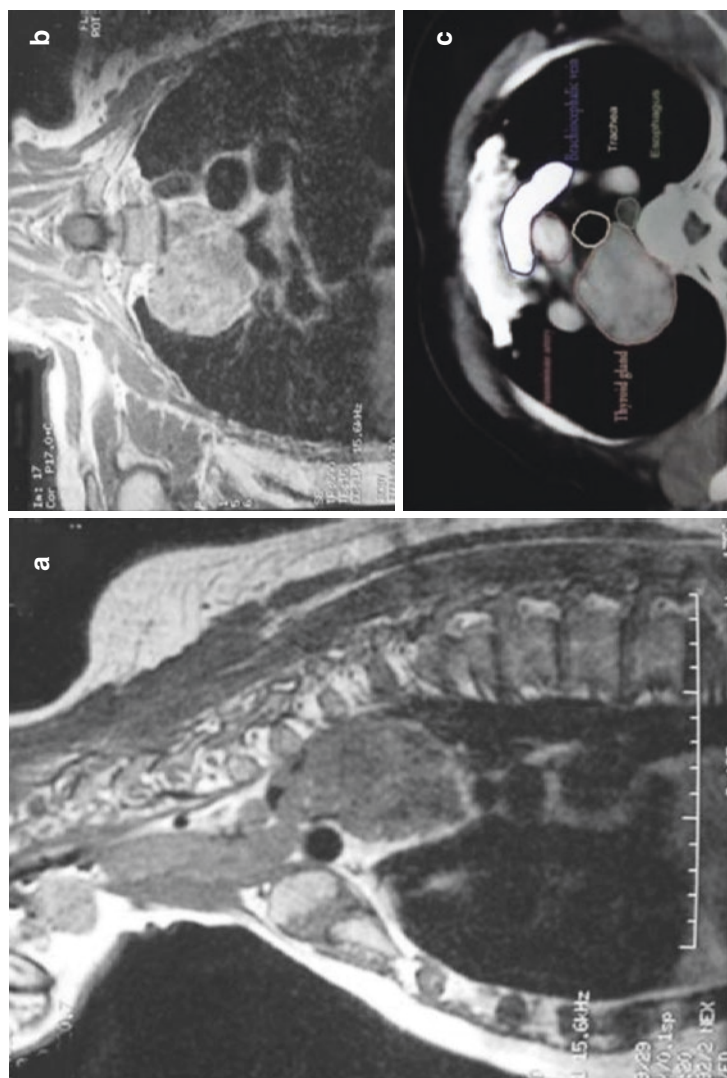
Voluminous posterior mediastinal goiter. MRI T1-w sagittal and coronal plane and CT scan axial plane after intravenous contrast administration
